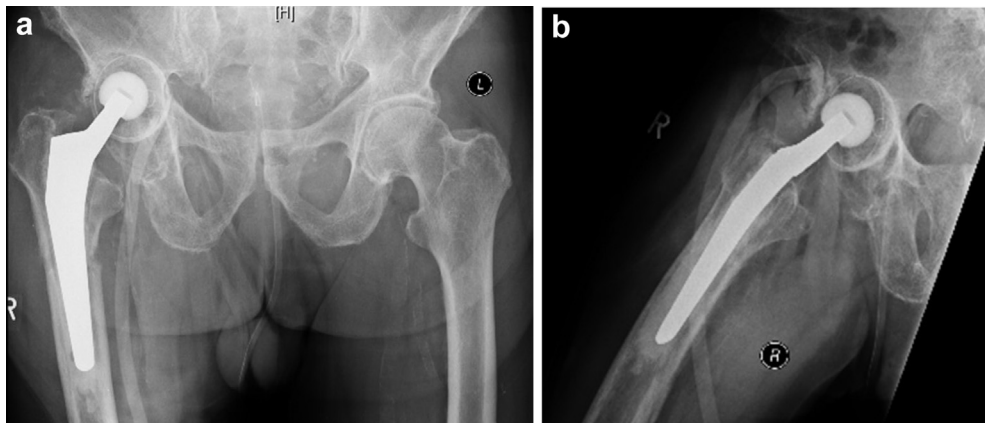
Anteroposterior (AP) (a) and lateral (b) radiographs depicting a patient with a Paprosky type IIIA defect.
